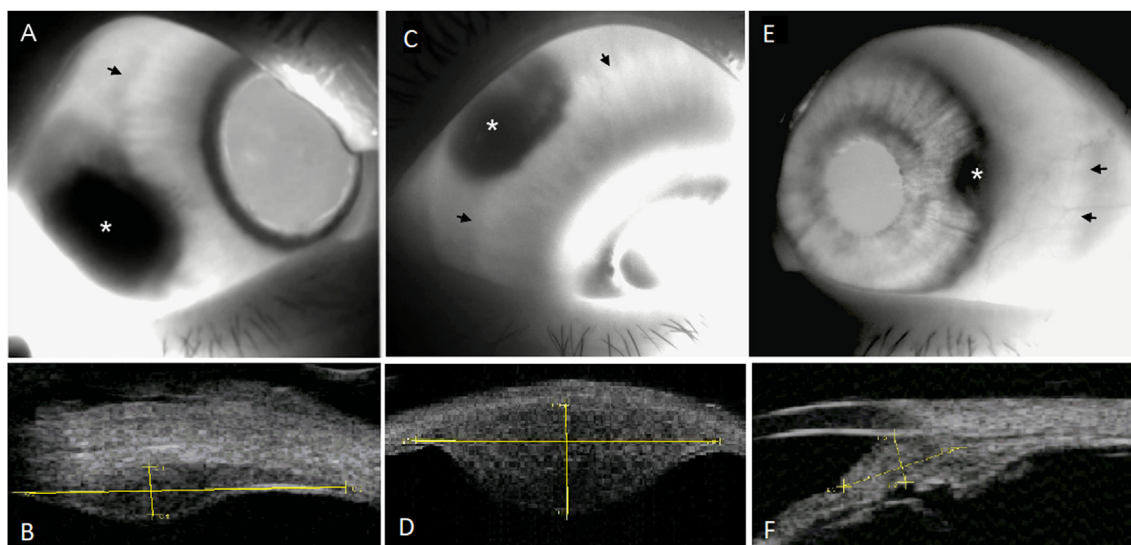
A. NIR transillumination image of the uveal melanoma located in the lower temporal portion of the right eye of a 55-year-old woman. Note the irregular shadow in the projection of uveal melanoma (white asterisk) and its contact with pars plana of the ciliary body (the ora serrata is marked with a black arrow). The maximal diameter of the shadow of the tumour is 7.0 mm. B. Ultrasonographic image of the same tumour with a flat margin (the maximal diameter is 6.3 mm). C. NIR transillumination image of the uveal melanoma located in the upper temporal segment of the right eye of a 47-year-old woman. The shadow of the tumour is marked with a white asterisk and the shadow of ora serrata is marked with a black arrow. D. Ultrasonographic image of the same patient's eye. E. NIR transillumination image of the iris melanoma (with invasion to the pars plicata) located in the temporal area at the angle of the anterior chamber of the left eye of a 40-year-old woman. The shadow of the tumour is marked with a white asterisk and the shadow of ora serrata is marked with a black arrow. F. Ultrasonographic image of the same eye.
